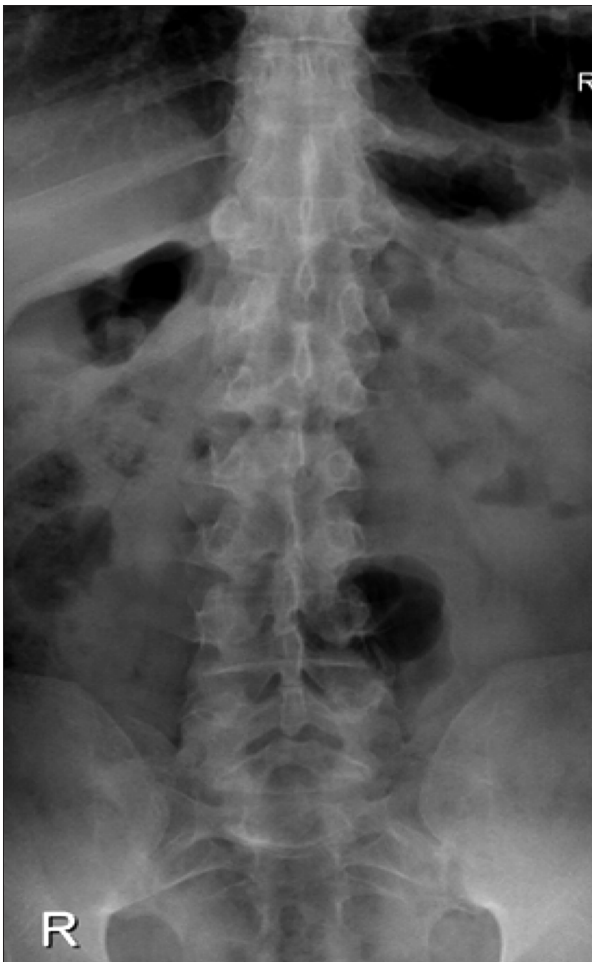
X-ray of the lumbar area shows mild spondylitic changes with relative decreased L5–S1 disc space posteriorly with noted facet joints arthropathy
